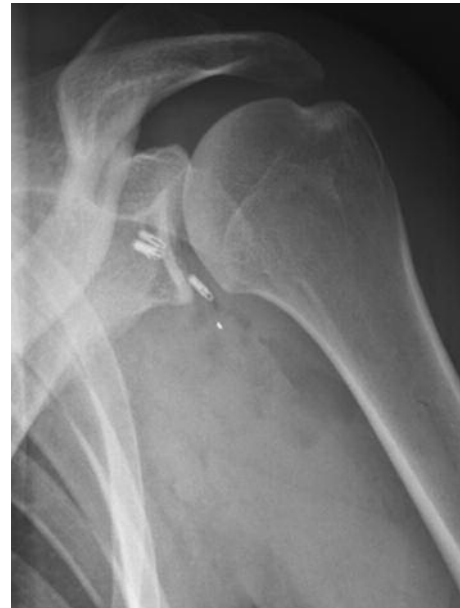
Arthrography of the left shoulder (prior to arthro-MRI scan) showing migration of the extra-osseous anchor (arrow) into the glenohumeral joint.
